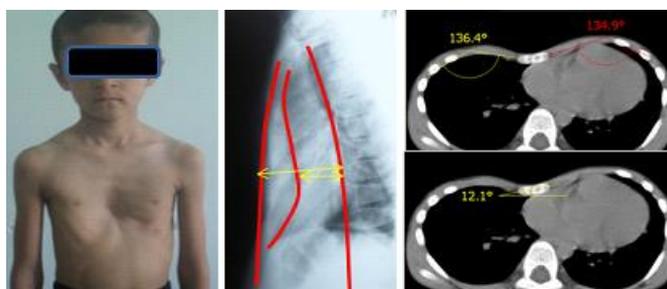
a, b, c, G. Patient Z., age with PE, symmetrical appearance, grade II, appearance, X-ray and computer tomography.
